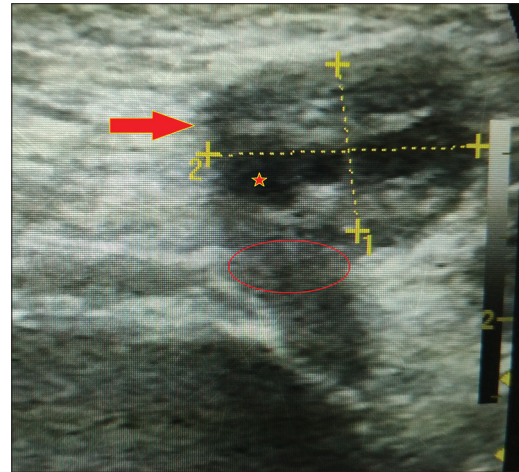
Longitudinal gray-scale ultrasonography showing an echogenic, ovoid, solid mass (arrow) containing cysts in the left inguinal area, which extends to the abdominal cavity through the neck of the canal of nuck (circle). The small cysts are the follicles in the normal ovary (star)
